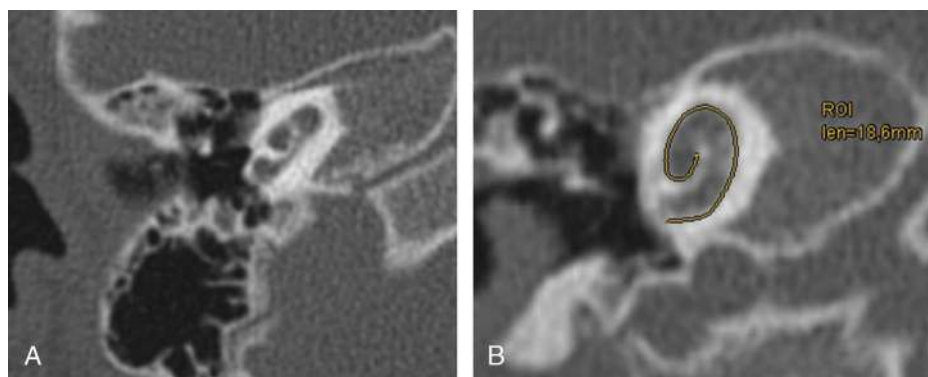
Axial HR-CT scans of the cochlea. Hypoplasia of the cochlea (A). Length of the cochlea 18.6 mm (B).
